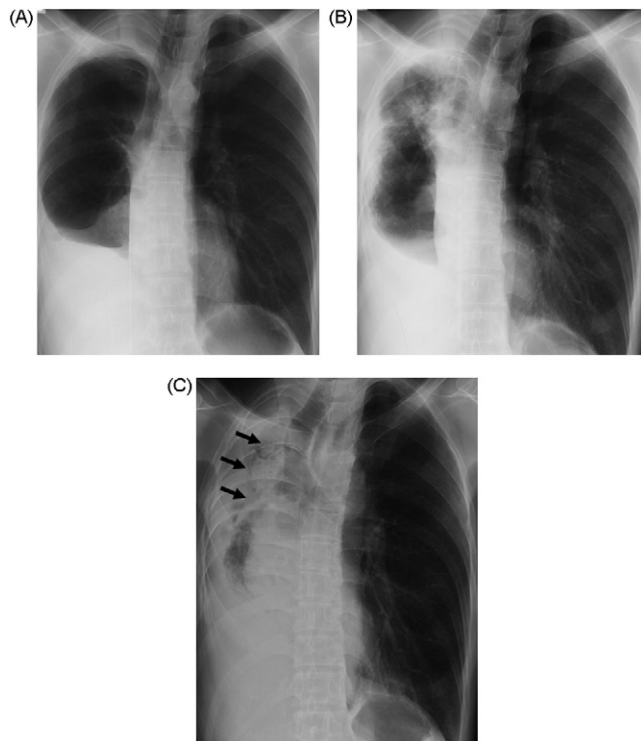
The chest roentgenogram reveals a smooth and clear lung margin (A) that changed to an irregular one with thickness and infiltration (B). These changes progressed throughout the residual lung and were followed by scarring and retraction of the residual lung and large cavity formation. Finally, total destruction of the residual lung, overinflation of the contralateral lung, and a mediastinal shift occurred (C). The case presented here shows fungal infection in the large cavity 13 years after lobectomy (C, arrows).
